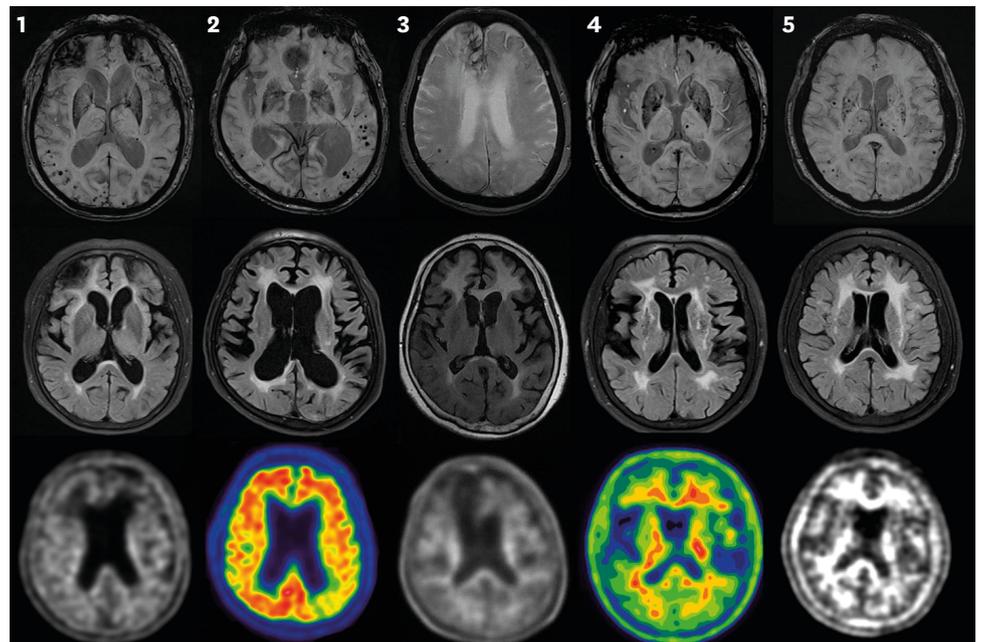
Brain magnetic resonance imaging shows microbleeds (upper), white matter hyperintensities and lacunes (middle), and amyloid PET findings (lower) from each case (from case 1 [left] to 5 [right]). Florbetaben PET scans in case 1, 3, and 5; flutemetamol PET scans in case 2; and florapronol PET scans in case 4. PET: positron emission tomography.
